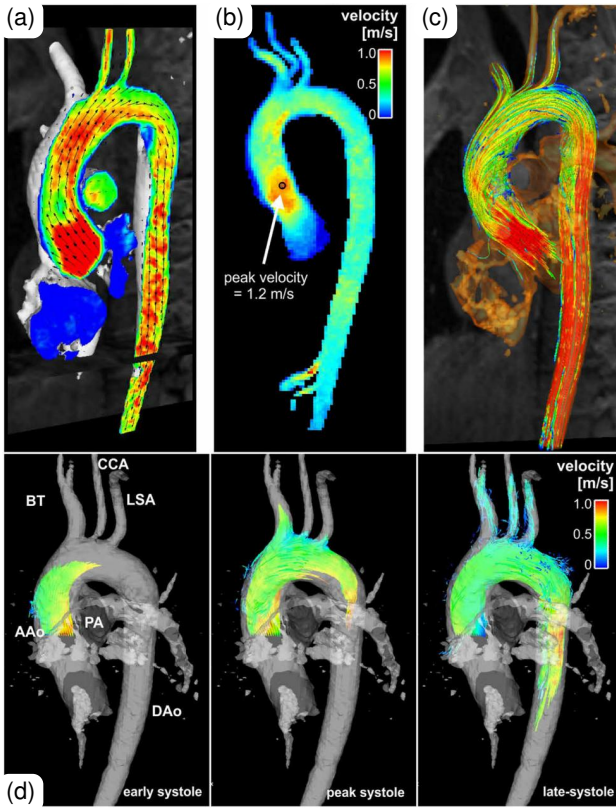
Visualization of aortic flow based on 4D flow MRI in clinical practice. Image from Dyverfeldt et al. [44], licensed under CC-BY.
